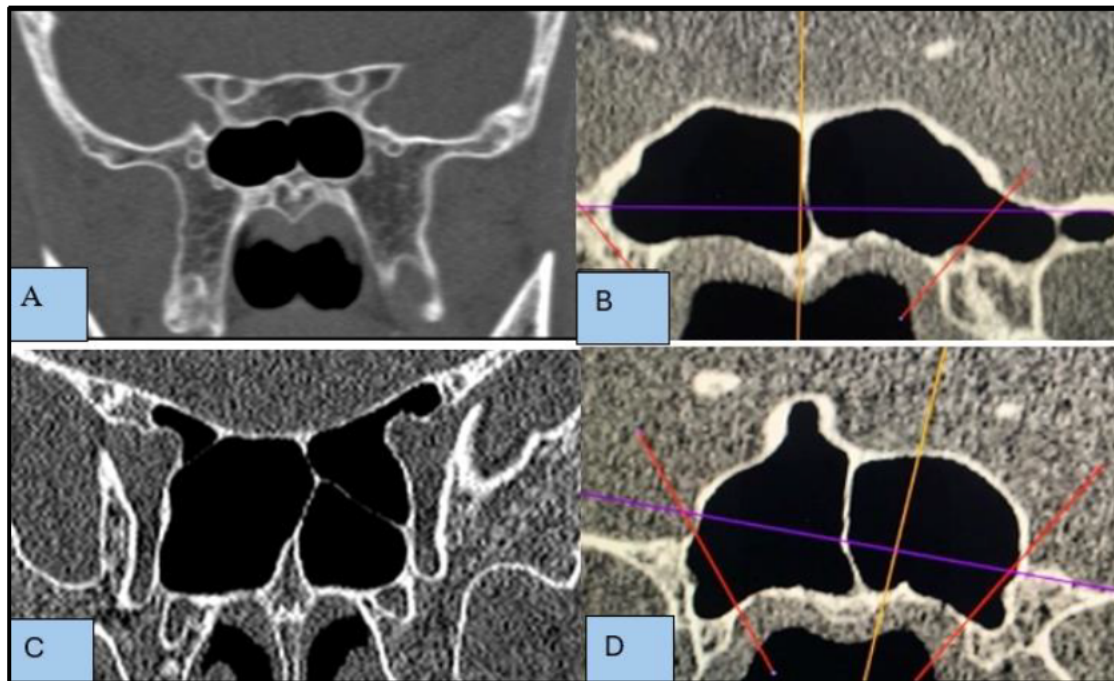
Coronal CT scans showing different types of lateral extensions of SS.
